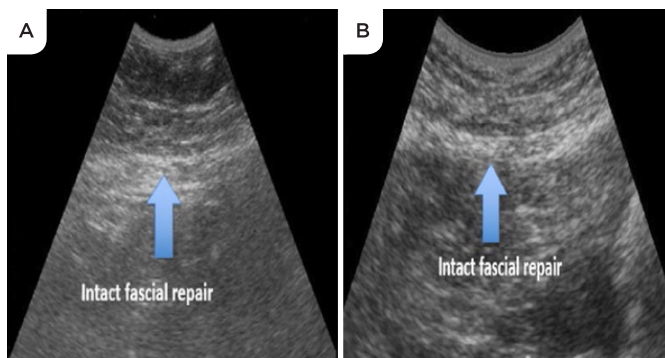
Abdominal wall ultrasound imaging depicting repaired fascia demonstrating a recognizable, robust, intact fascial layer without recurrent herniation. (A) Ultrasound of abdominal wall two and a half years after ventral hernia repair with Gentrix reinforcement. (B) Ultrasound of abdominal wall in a separate patient three years after ventral hernia repair with Gentrix reinforcement.
